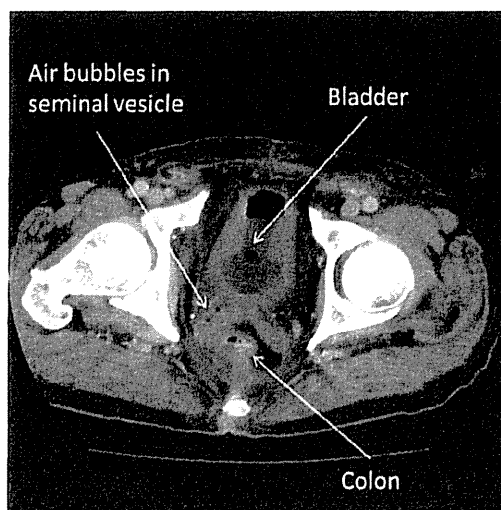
CT showing air bubbles in and around the seminal vesicle. This slice is 1 cm above the anastomotic site. 125 × 125 mm (150 × 150 DPI)
